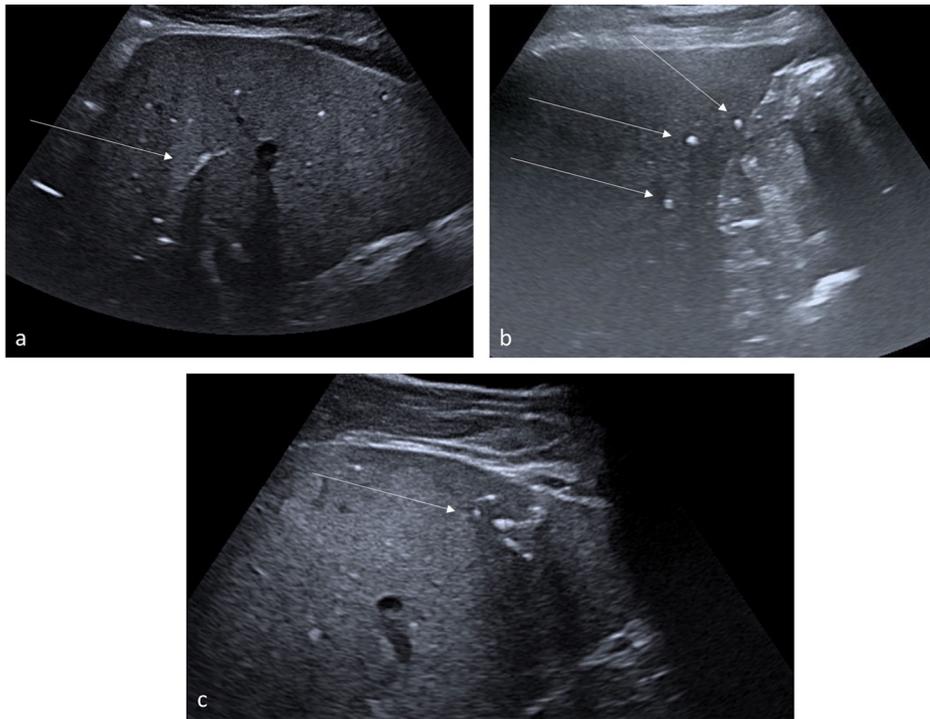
B-mode ultrasound imaging; a: Comet-tail image with posterior acoustic shadowing in the right lobe (arrow); b: hyperechoic intrahepatic calculi in the left lobe (arrows); c: peripheral lithiasis of the left lobe, hyperechoic, relatively extended (arrow). Different patients appear on each vignette.
